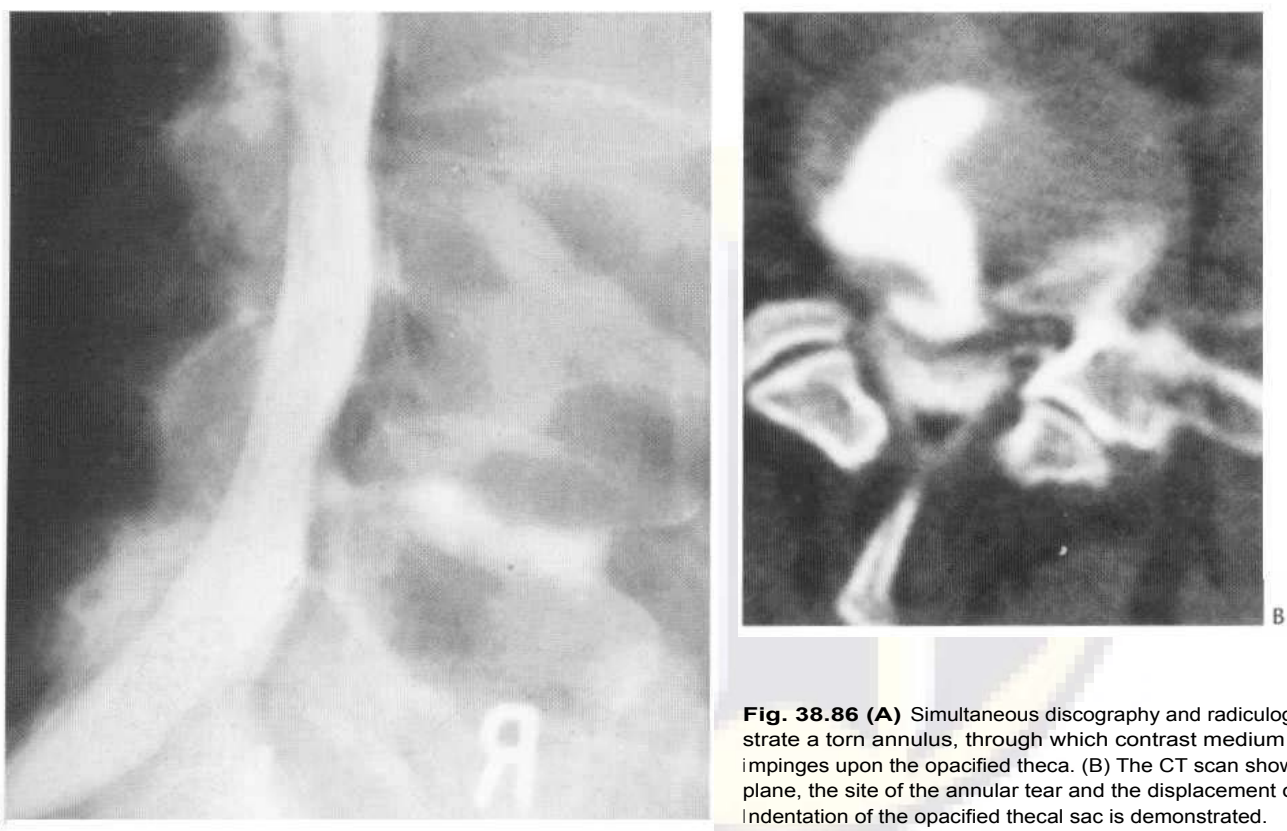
(A) Simultaneous discography and radiculography demonstrate a torn annulus, through which contrast medium escapes and impinges upon the opacified theca. (B) The CT scan shows, in the axial plane, the site of the annular tear and the displacement of the nucleus. Indentation of the opacified thecal sac is demonstrated.
